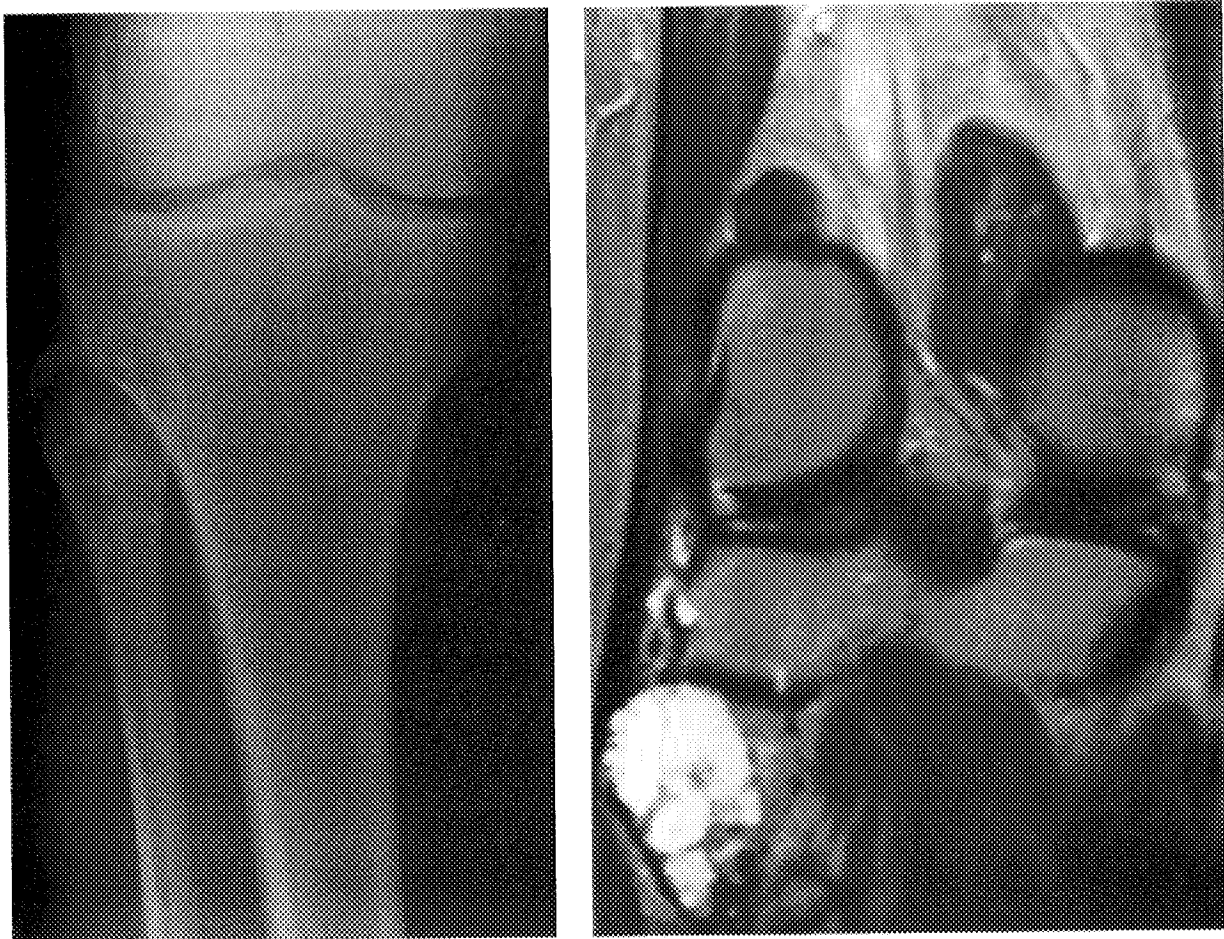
AP radiograph and sagittal T2-weighted MRI of a 30-year-old woman with pain in the lateral aspect of the knee. There is a destructive-appearing cartilaginous lesion in the proximal fibula. Because of the invasive nature of the lesion, an en bloc resection was performed without biopsy.
